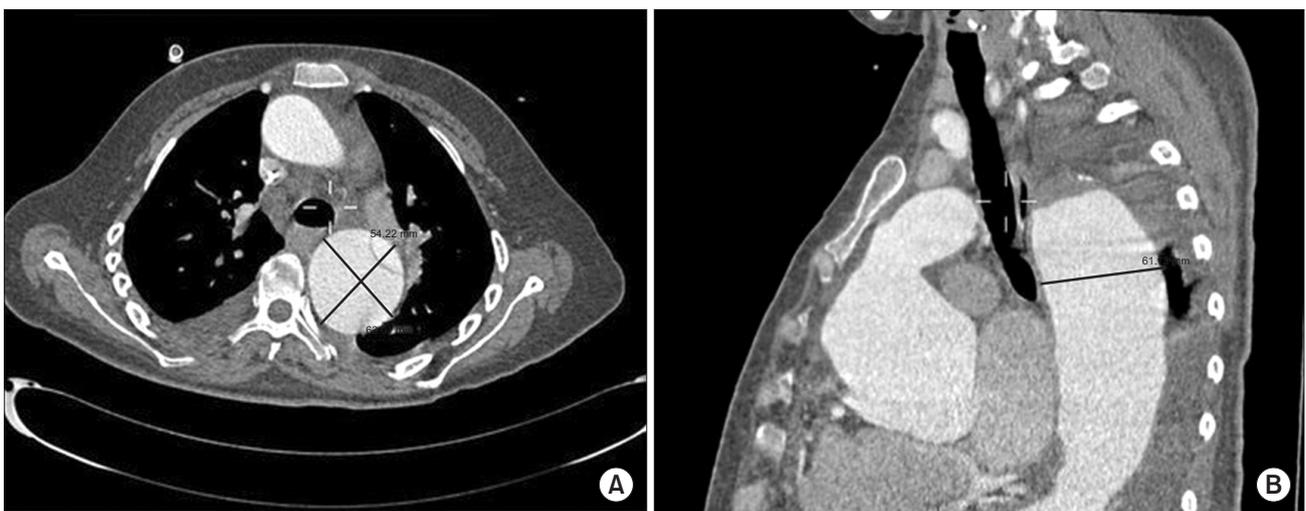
Chest computed tomography angiography shows the maximum diameters of the descending thoracic aorta in (A) axial view (6.6 cm) and (B) lateral view (6.1 cm).
